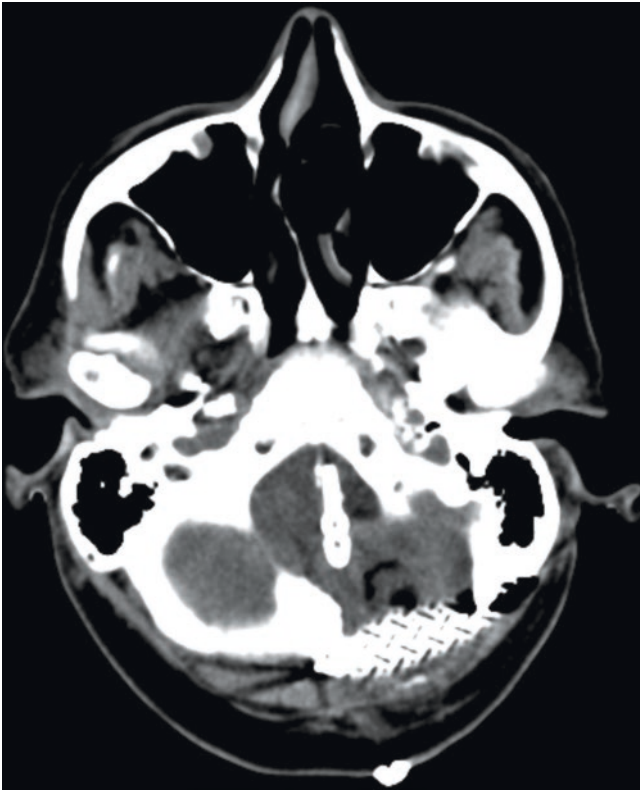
Postoperative CT
